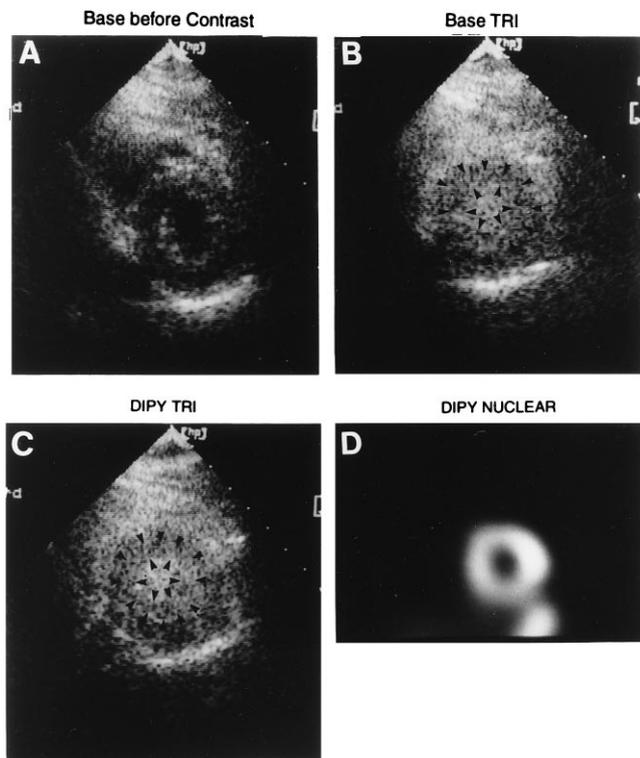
Myocardial contrast enhancement from the parasternal short-axis view in another patient (primary view in this patient). Arrows enclosing endocardial and epicardial borders depict normal contrast enhancement under rest conditions and during peak dipyrindamole stress. The corresponding stress tracer uptake is also shown and was also quantitatively normal. DIPY = images obtained during dipyrindamole stress; TRI = triggered imaging (one frame every cardiac cycle in this primary view).
